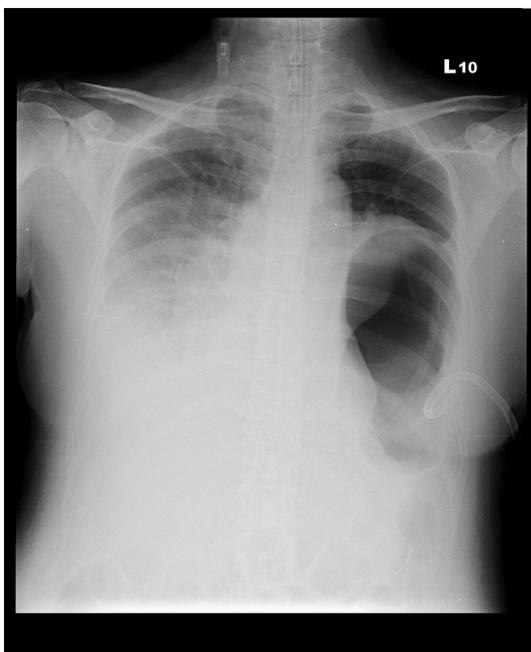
Follow-up chest radiography showed intrathoracic stomach with nasogastric tube, the pigtail catheter was placed in the pleural cavity.
